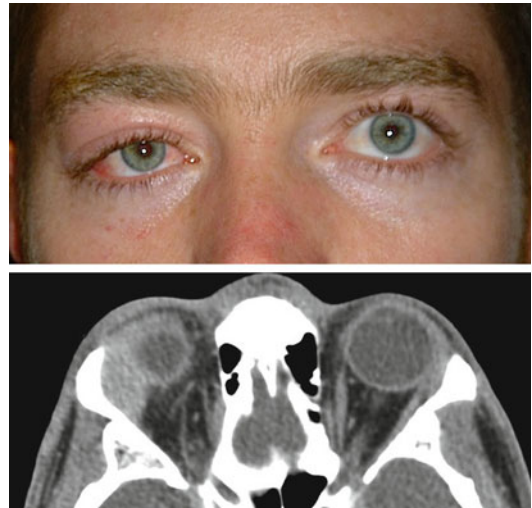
Acute dacryoadenitis with CT identifying enlarged orbital lobe of lacrimal gland
